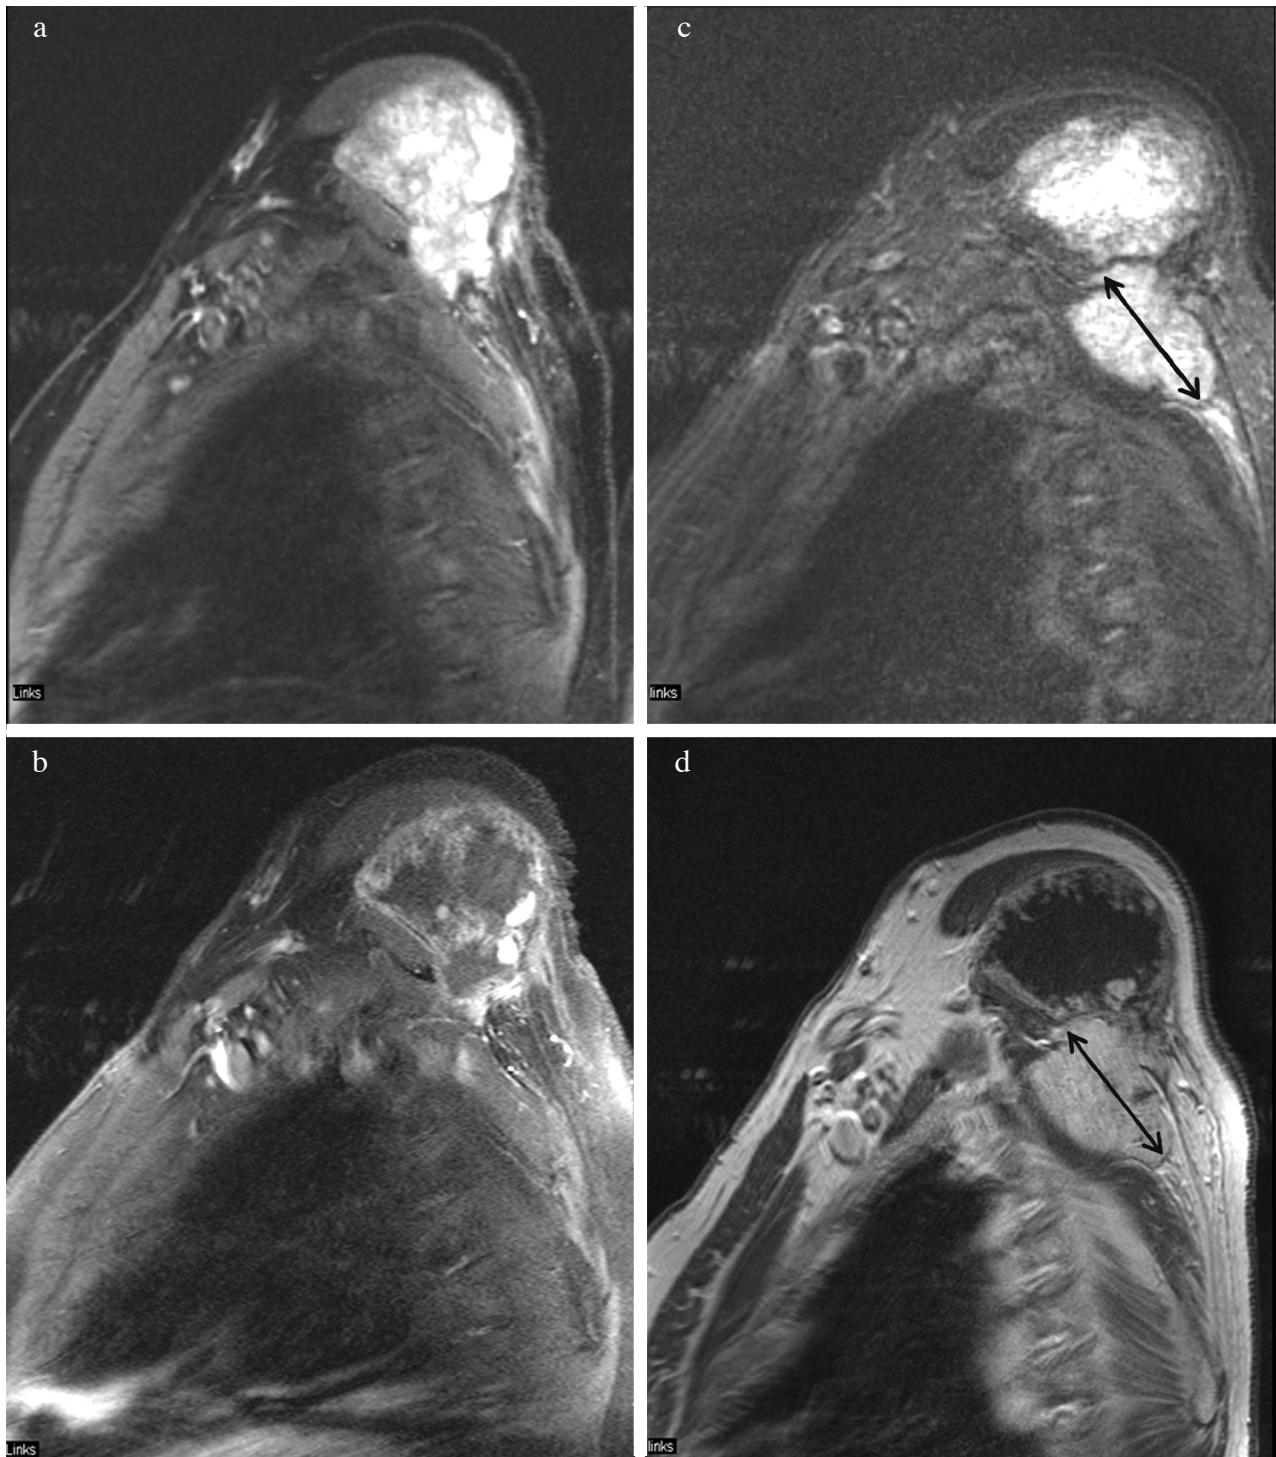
Magnetic Resonance Images (MRI) of the left scapula in the parasagittal plane: On the left side (3a, b), MR-images of the year 2000 are shown: A huge tumorous mass, in the soft tissue beneath the deltoid muscle is visible. The lesion measures 11x7x9 cm in size. On fat-suppressed images (3a), a hyperintense, inhomogeneous signal results whereas after contrast application (3b) a rich enhancement is shown indicating a necrotic central zone. On the right side (3c, d), MR-images 3 years later are displayed: A second tumor nodule is now recognizable, located just dorso-caudal to the primary tumor mass (indicated by the red arrow). This nodule is of homogeneous hyperintense signal on fat-suppressed images (3c) and shows homogeneous contrast enhancement (3d) indicating viability.
